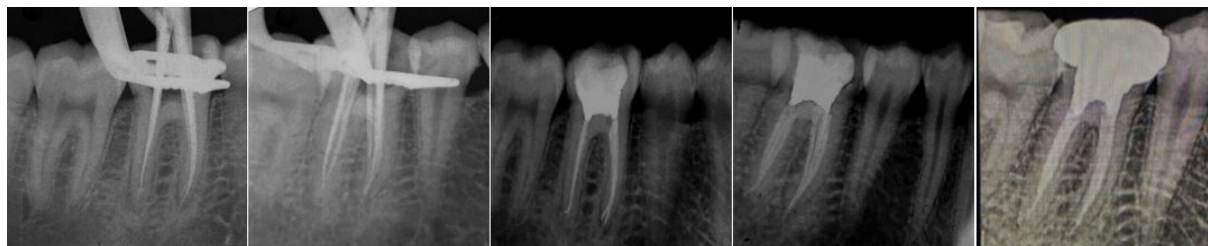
A) Master cone radiograph. B) The master cone radiograph was taken at the distal angulation. C) Postoperative radiograph; 6 canals were obturated. D) Postoperative radiographs taken from the distal aspect; 6 canals were obturated. E) Recall radiograph 1 year after the completion of the treatment.
